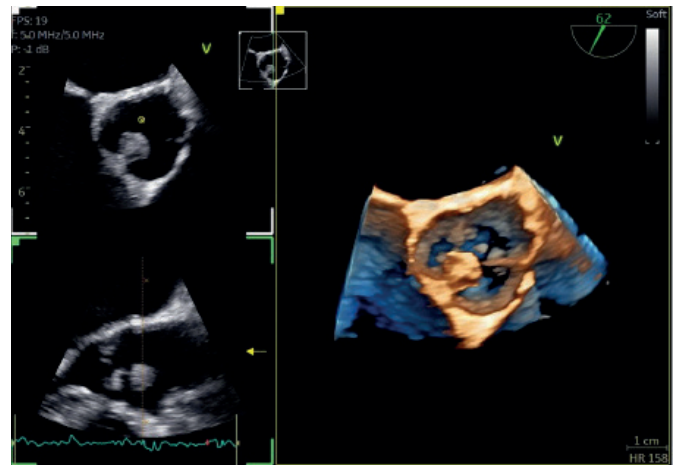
3-D Transoesophageal Echocardiography (TOE) imaging confirming the presence of the aortic mass.
